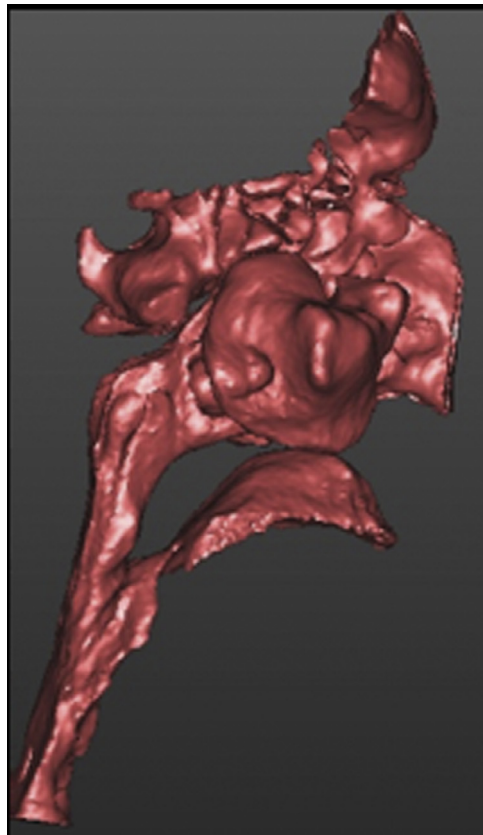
3D image of the airway obtained from CBCT data.
